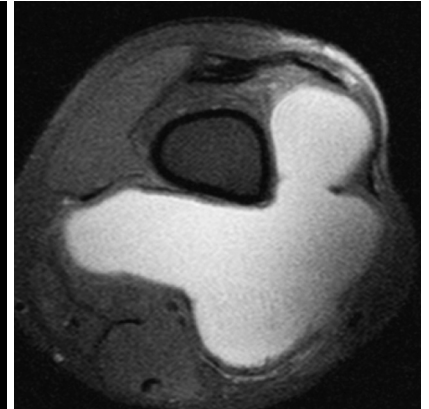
Axial section of the MRI scan showing the extent of the swelling and the involvement of various structures
